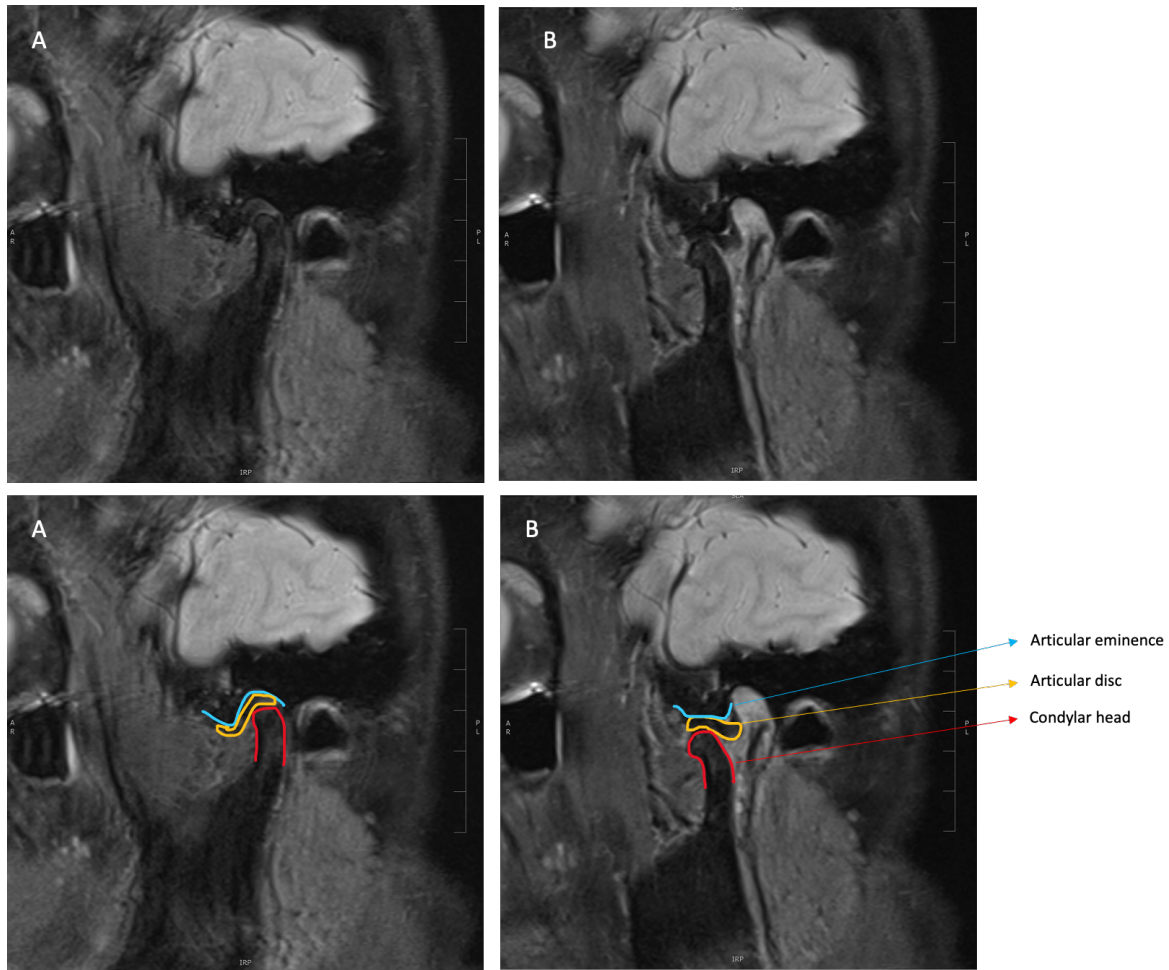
MRI view of TMJ showing normal TMJ. MRI sagittal view of TMJ showing normal TMJ-disc relationship in both A) closed and B) open position.
